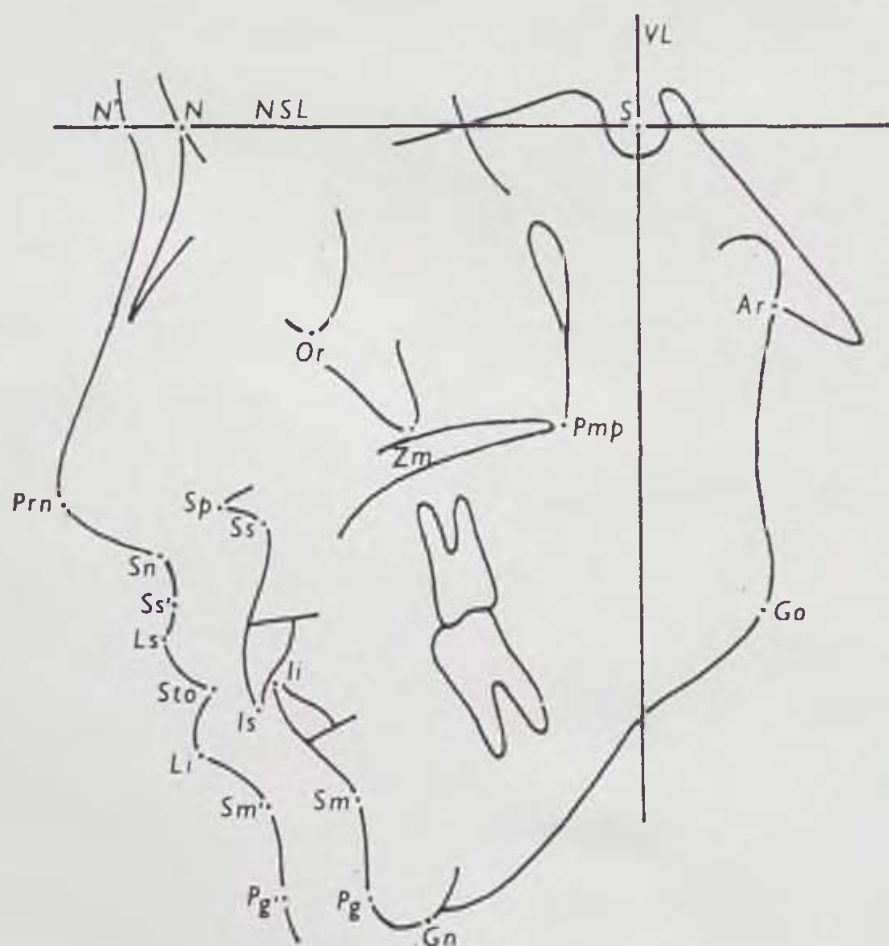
Cephalometric points used for the assessment of lateral X-ray films.
